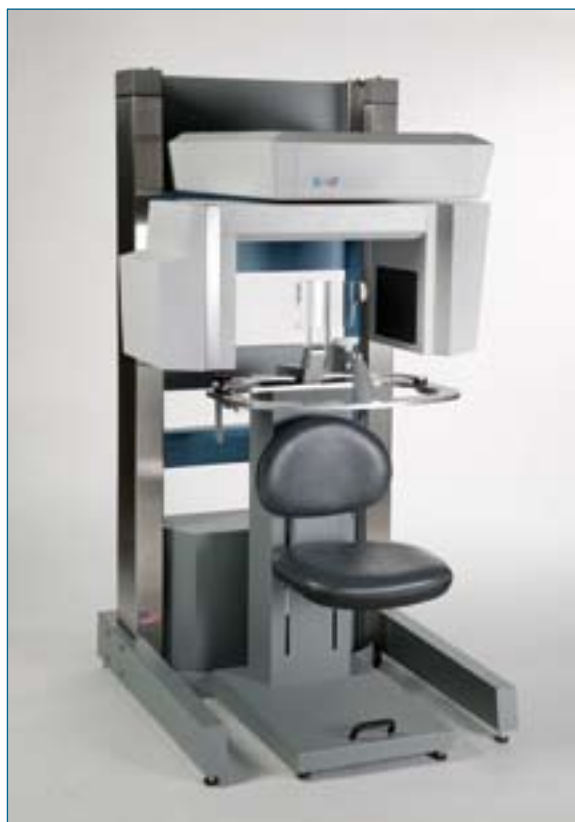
The i-CAT cone beam CT scanner (Imaging Sciences International).
